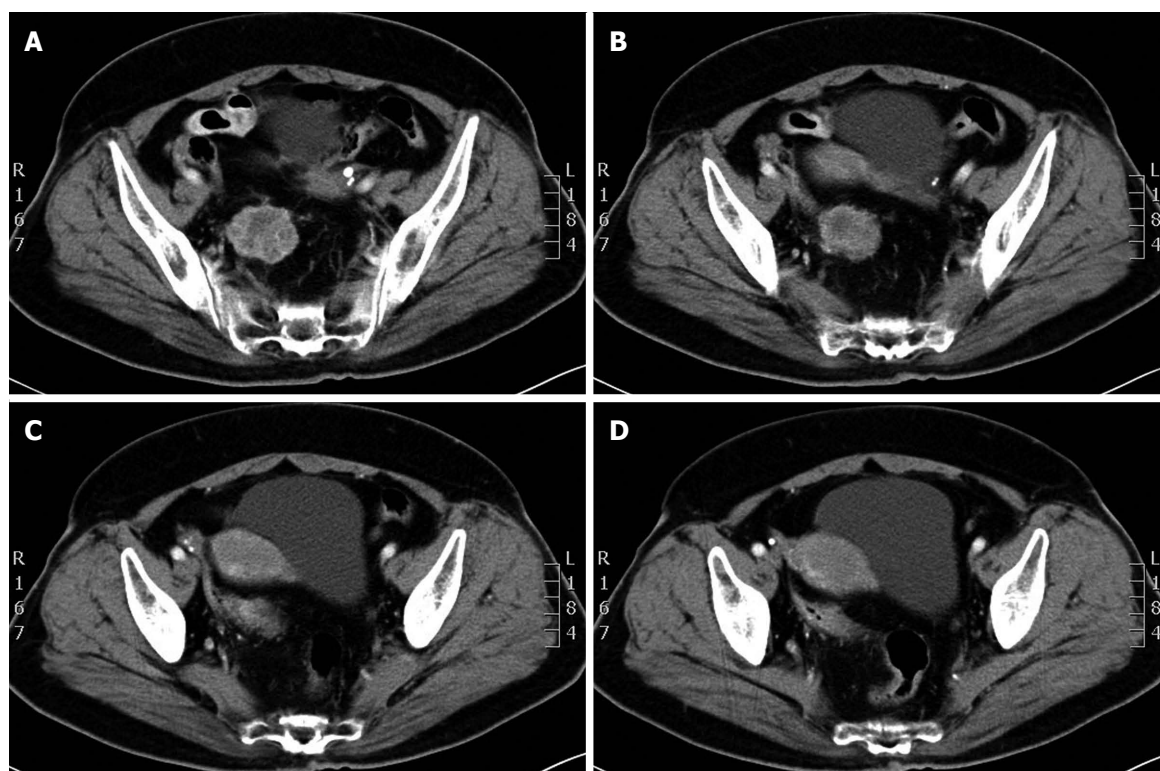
Contrast enhanced computed tomography showing a pelvic soft-tissue lesion which had heterogeneous density in the venous and delay phases, respectively.
